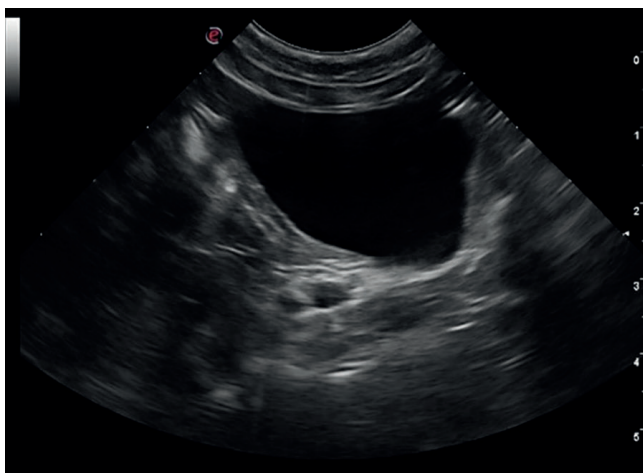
Ultrasonographic appearance of the bladder 3 months after initiation of the therapeutic protocol. Normotonic bladder, homogeneous anechoic content, specific parietal architecture.
